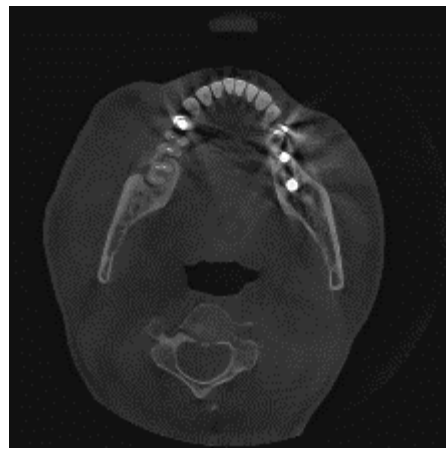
CBCT image shows radiolucent lesion on right 2nd molar teeth of mandible
